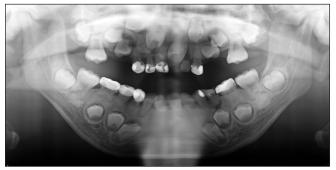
Panoramic radiographs taken at 9 years and 7 months of age: The succedaneous teeth in the areas where the corresponding primary teeth had been extracted tended to erupt; however, in the other areas, this change was not noted.
